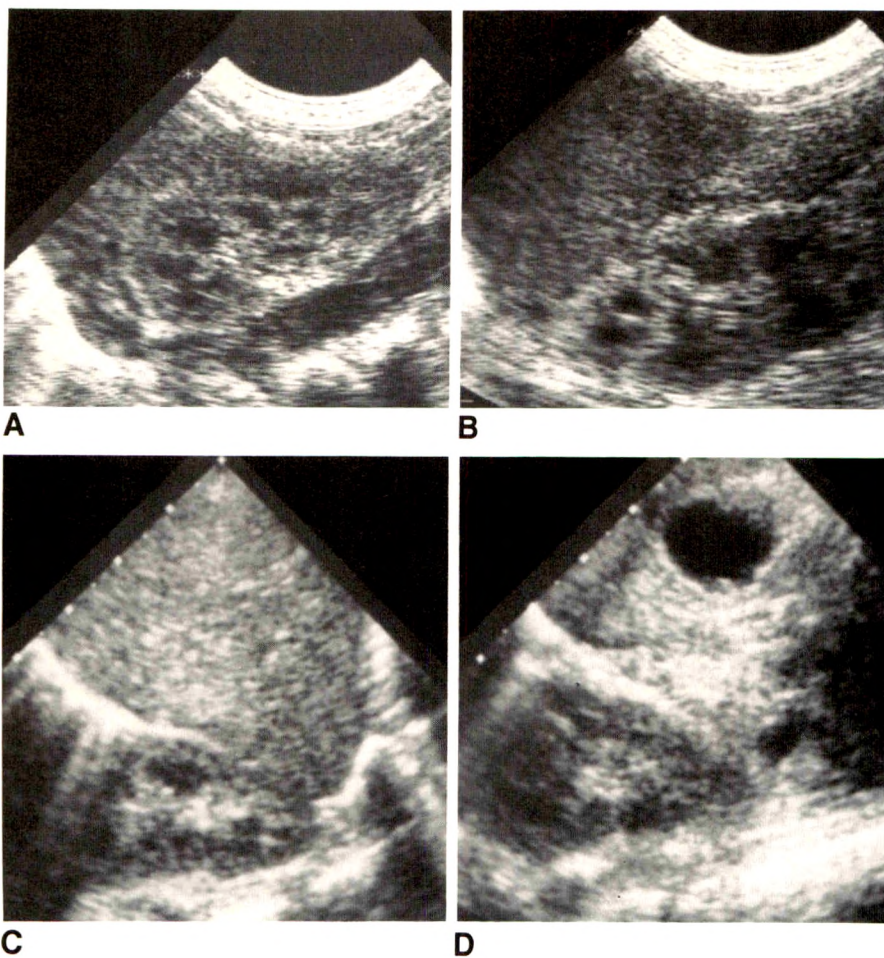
A and B, Longitudinal right (A) and left (B) sonograms obtained during neonatal period show kidneys below diaphragm on each side.
